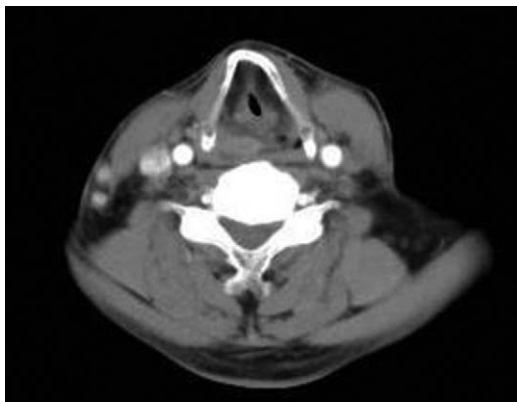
Neck-enhanced CT revealed thickening of the right posterior pharyngeal wall, and an image of soft tissue density was present on the posterior pharyngeal wall with a size of approximately 1.0 × 1.5 cm. CT = computed tomography.
